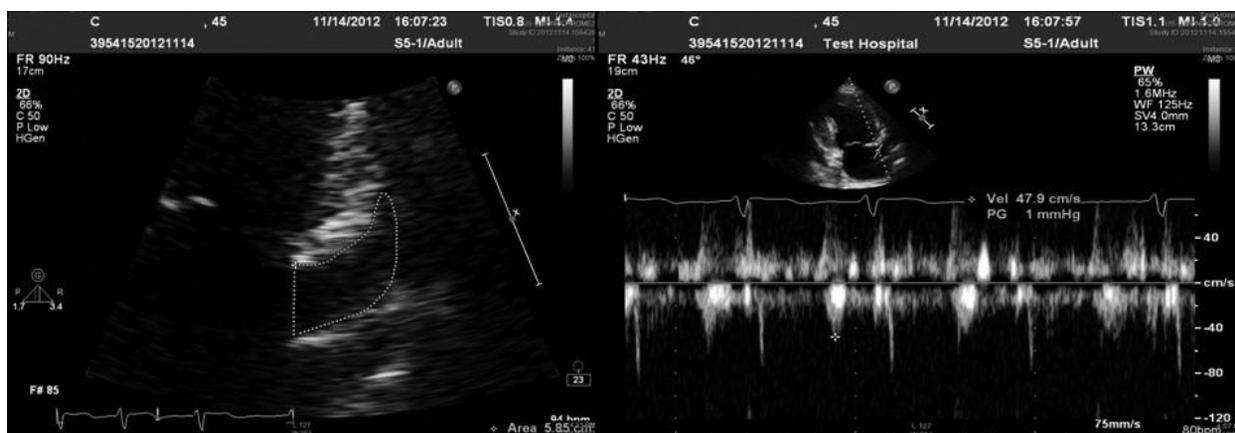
Assessment of left atrial appendage area and blood flow velocity by transthoracic echocardiography
